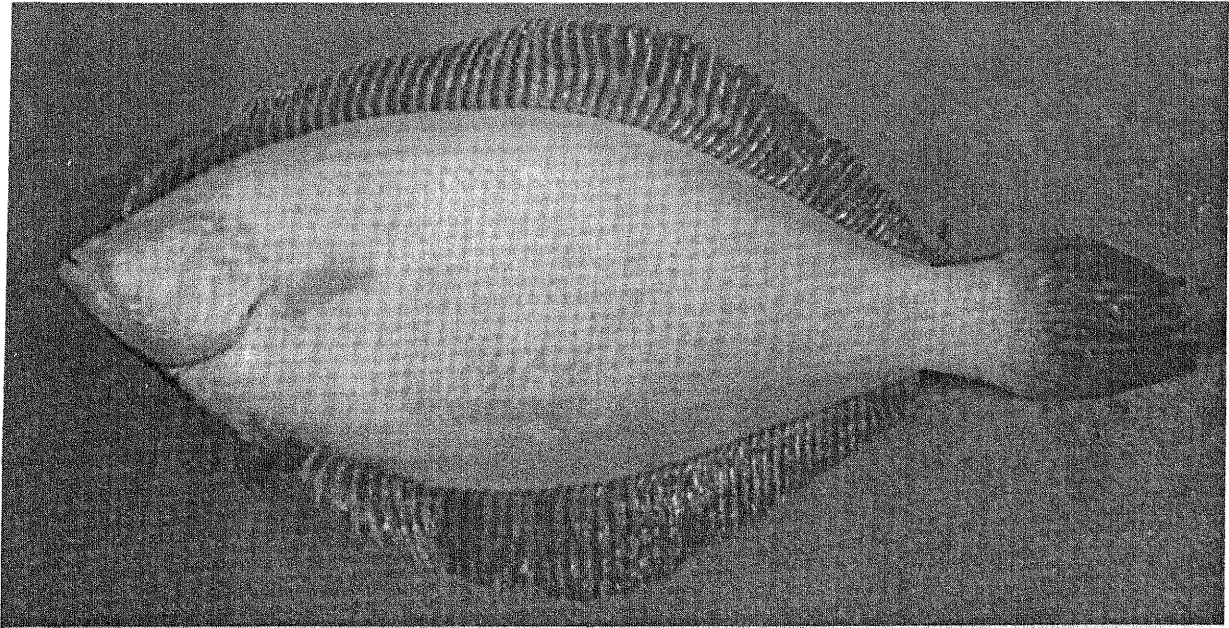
Bent fin rays in winter flounder from the New York Bight. External appearance (above) and radiograph (below).
